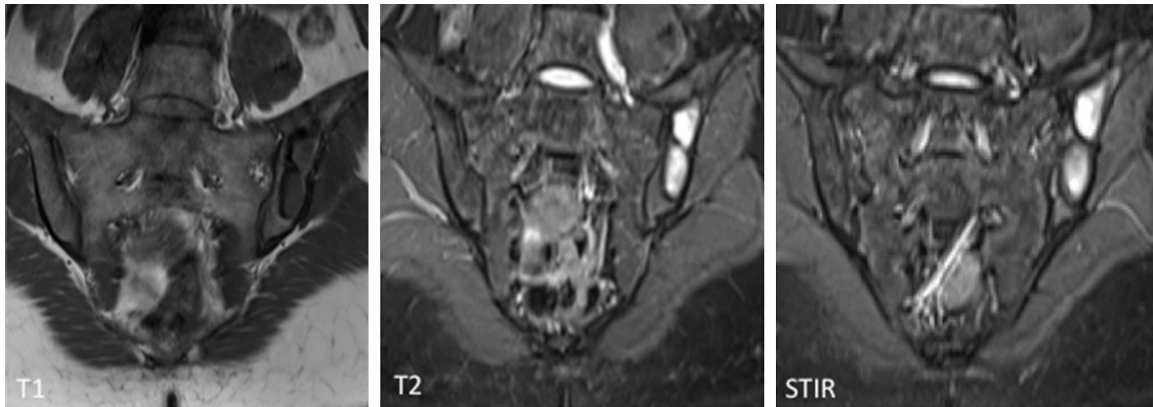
Sagittal MRI of the sacrum revealed the lesions located in left ilium, which were found to be low signal intensity on T1-weighted, high intensity on T2-weighted images and especially high intensity on STIR sequence.
